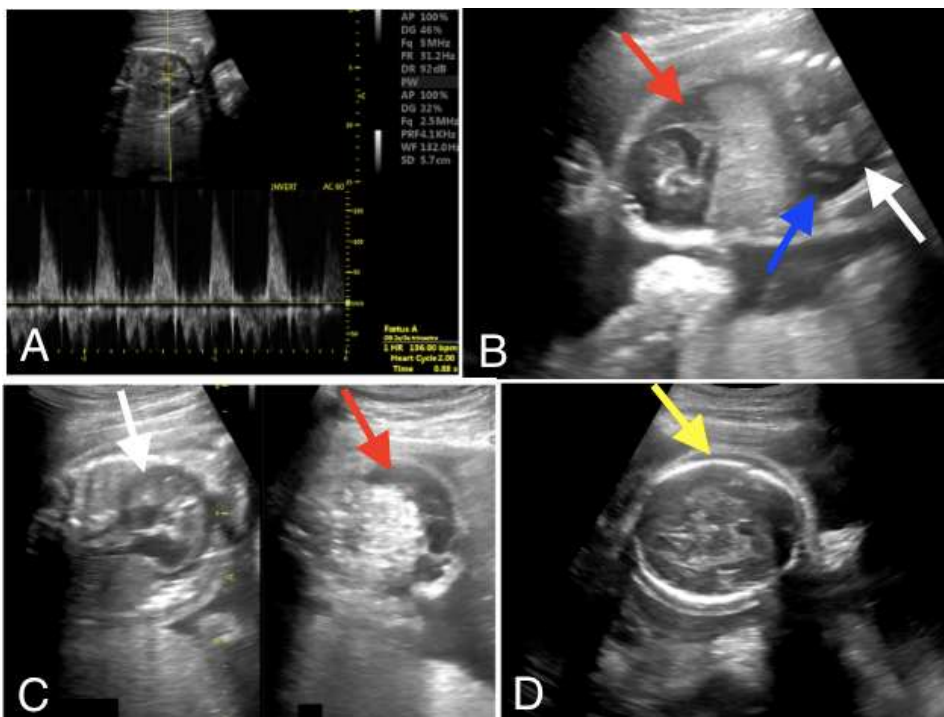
obstetric ultrasound at 27 weeks of amenorrhea: (A) measurement of fetal heart rate; (B) oblique view of the fetal chest and abdomen; (C) axial view of the fetal heart on the left and axial view of the fetal abdomen on the right; (D) axial view of the fetal head
